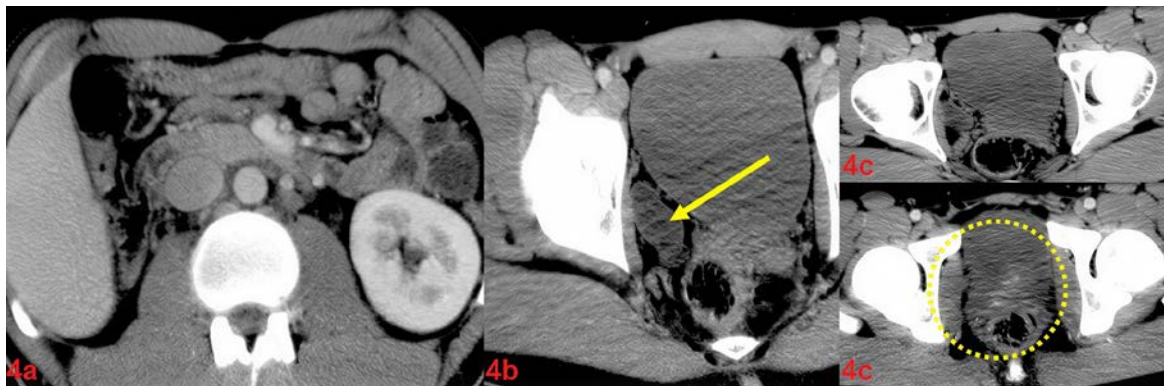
a-c Axial CT images (a) of the upper abdomen which reveals the absence of the right kidney, (b) at the level of the urinary bladder which show a cystic tubular structure (Arrow) and (c) CT images which show a mass projecting to the urinary bladder (Circle)
